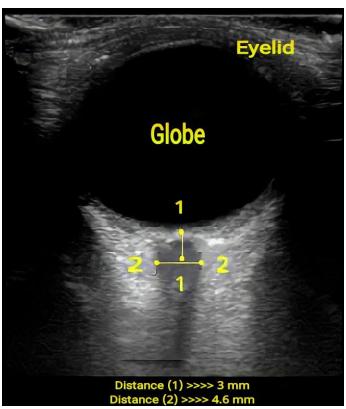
Sonographic measurement of ONSD of a case of the normotensive group.
